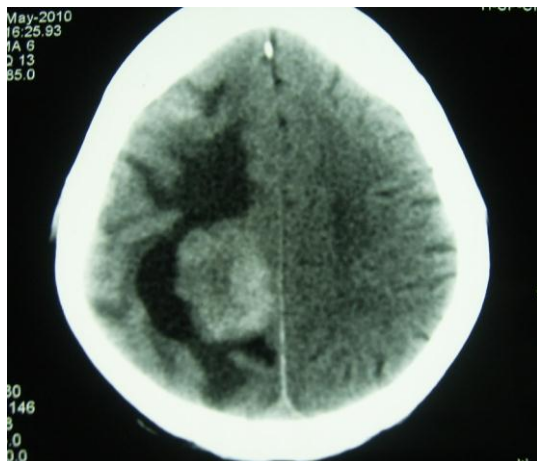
CT shows brain metastasis.
